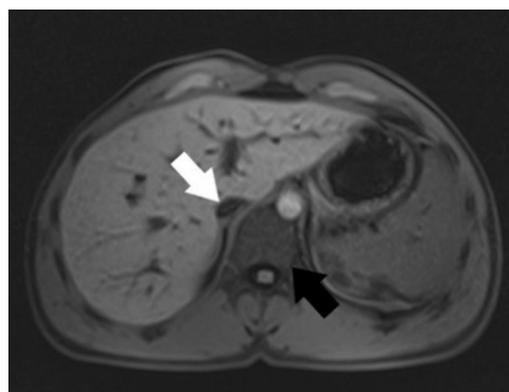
Axial fat-suppression T1-weighted image IVC images in a 26-year old man: IVC (white arrow) caudal to the hepatic vein-IVC junction, 12th thoracic vertebra (black arrow)
